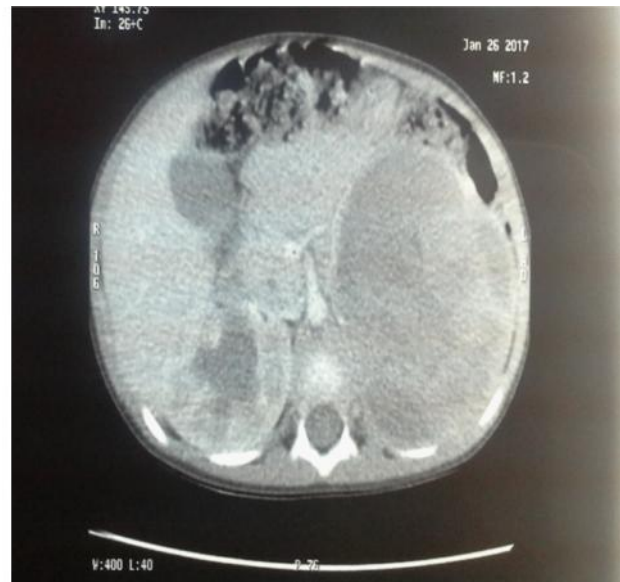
and 3B: A coronal reformat and axial image of the abdominal CT scan before neoadjuvant chemotherapy
